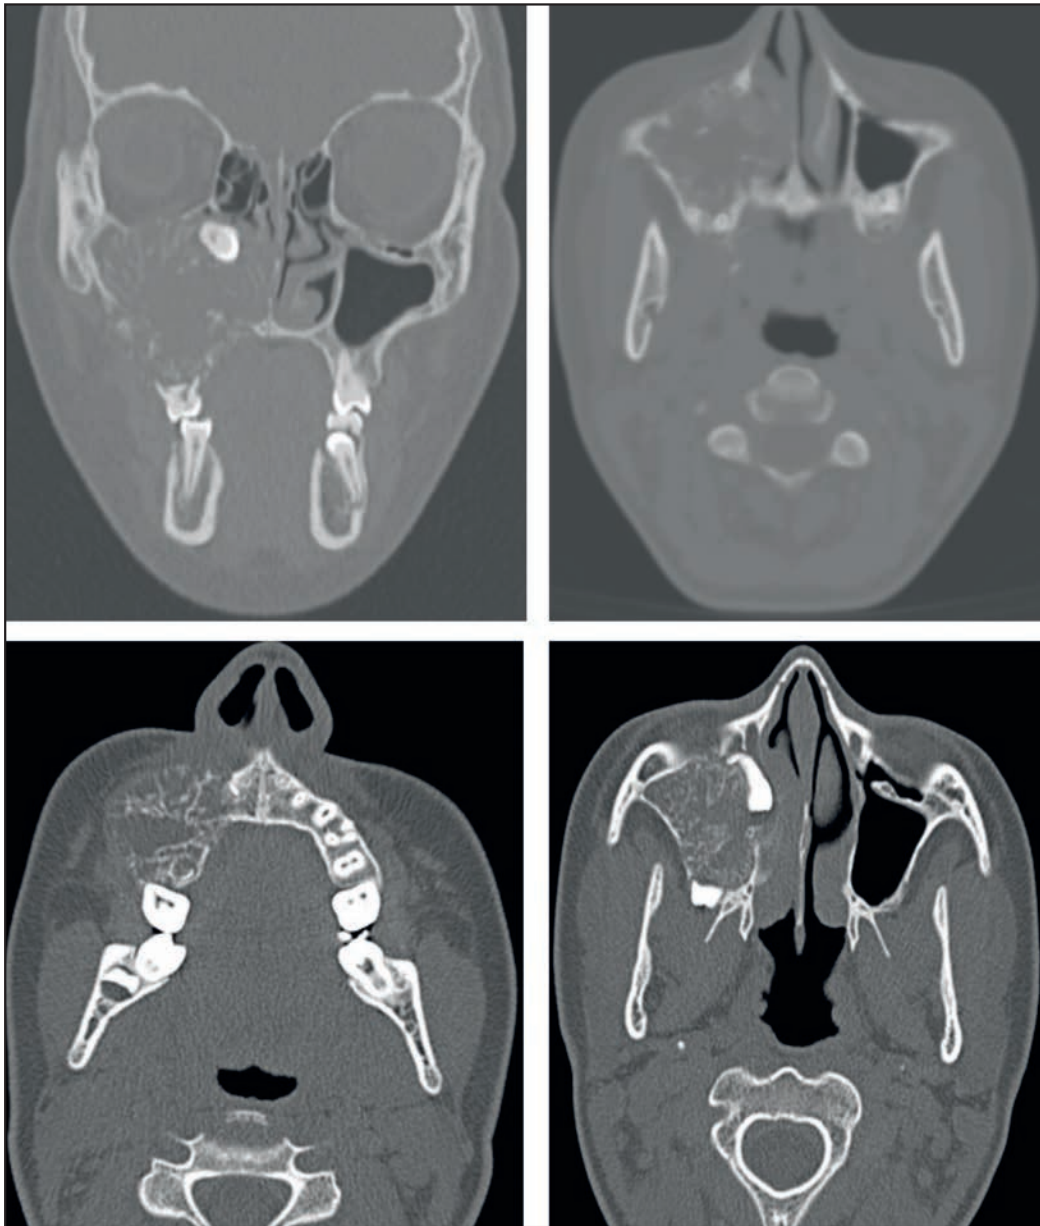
Preoperative cranio-facial CT scan (coronal and axial slices) – soft tissue mass occupying the right maxillary sinus; erosion of the anterior, medial and inferior maxillary walls
